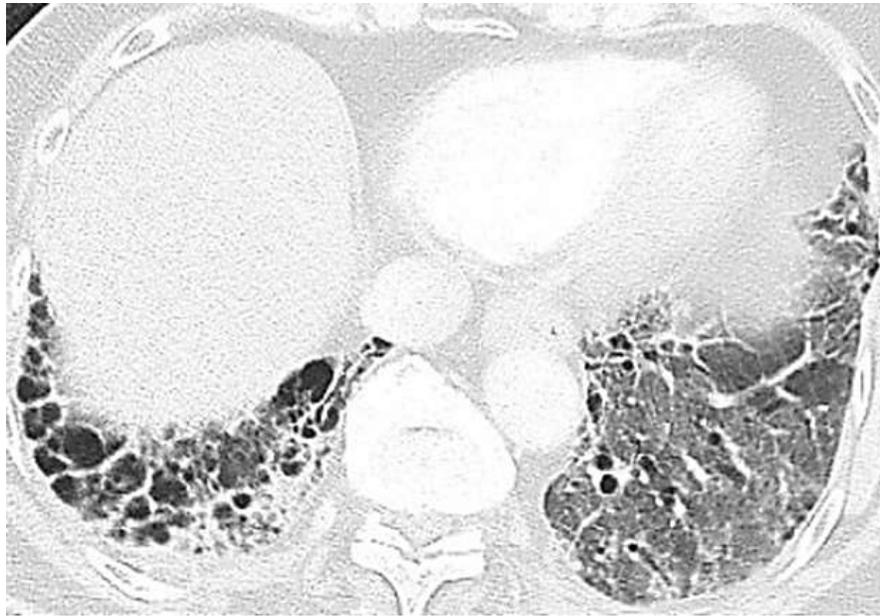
HRCT from a patient with IPF presenting with acute exacerbation. The scan shows new bilateral ground-glass opacities and consolidation superimposed on a background of usual interstitial pneumonia pattern with basal and subpleural predominance, reticulation, and honeycombing.
